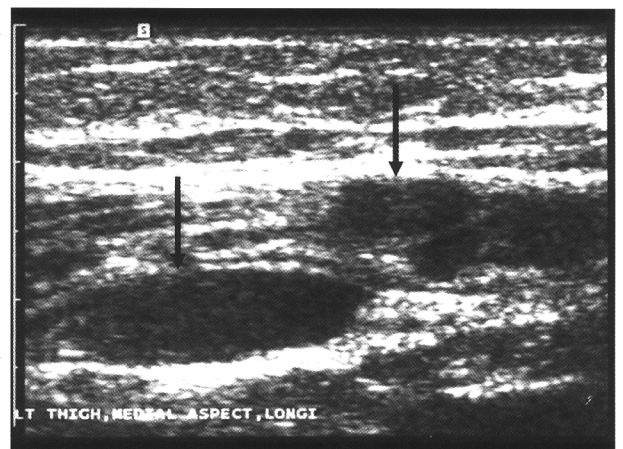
Ultrasonogram shows heterogeneous, hyperechoic mass with hypoechoic tubular lesion (arrows) in the sartorius muscle.
